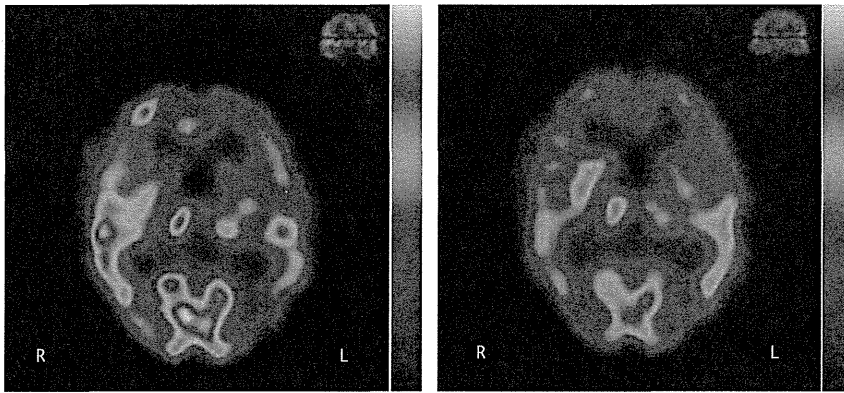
Single-photon emission computed tomography (technetium Tc 99m ethyl cysteinate dimer) images before (left) and after (right) the treatment.
